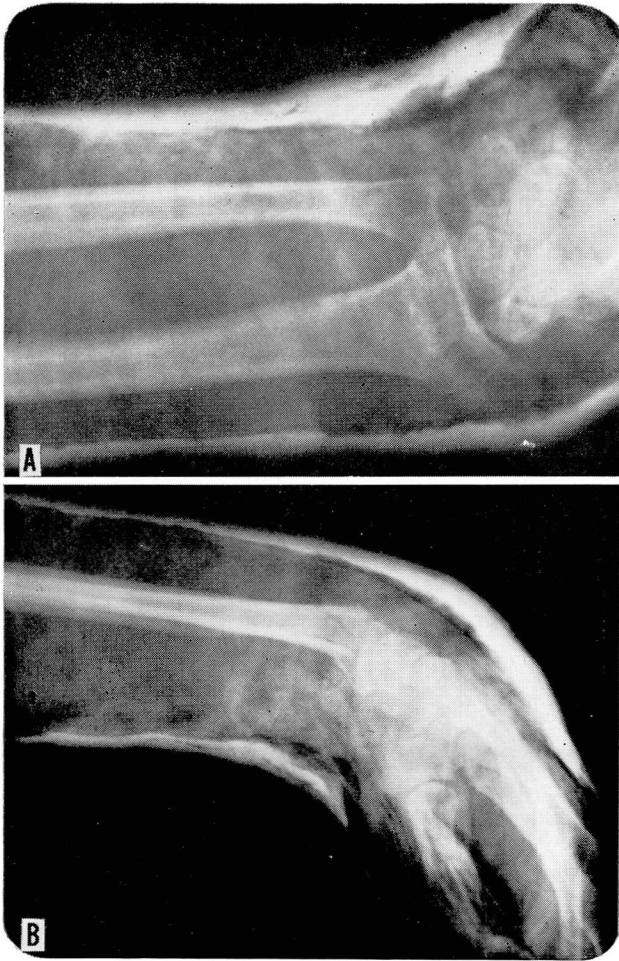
Posteroanterior (A) and lateral (B) roentgenograms immediately after reduction of the fracture.
